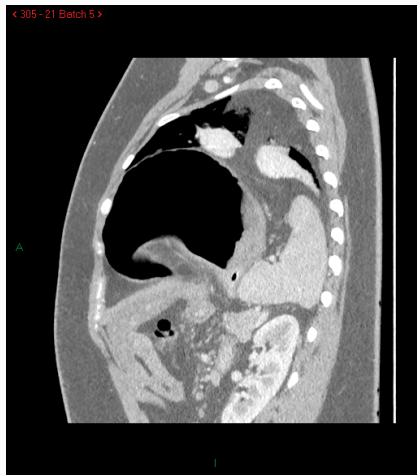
CT lateral view.
